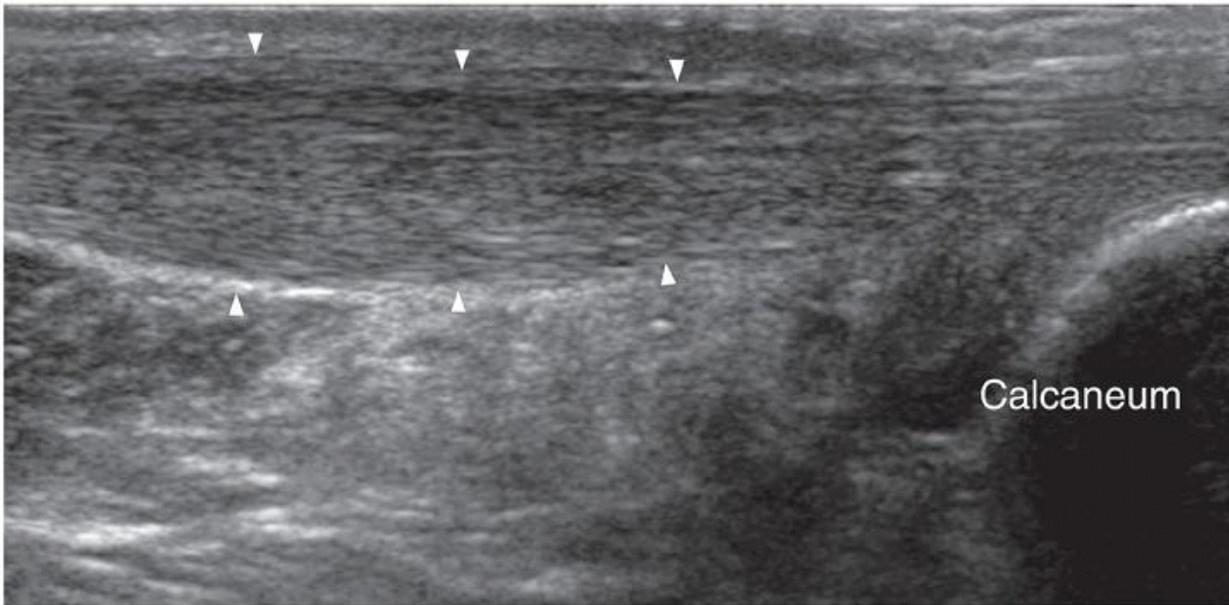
Longitudinal ultrasound showing moderate mid-portion Achilles tendinosis with moderate fusiform swelling and slight hypoechogenicity of the mid-third of the Achilles tendon (arrowheads). Color Doppler imaging (not shown) revealed mild intratendinous hyperemia. The distal one-third of the Achilles tendon is more normal in caliber and echo-texture.
